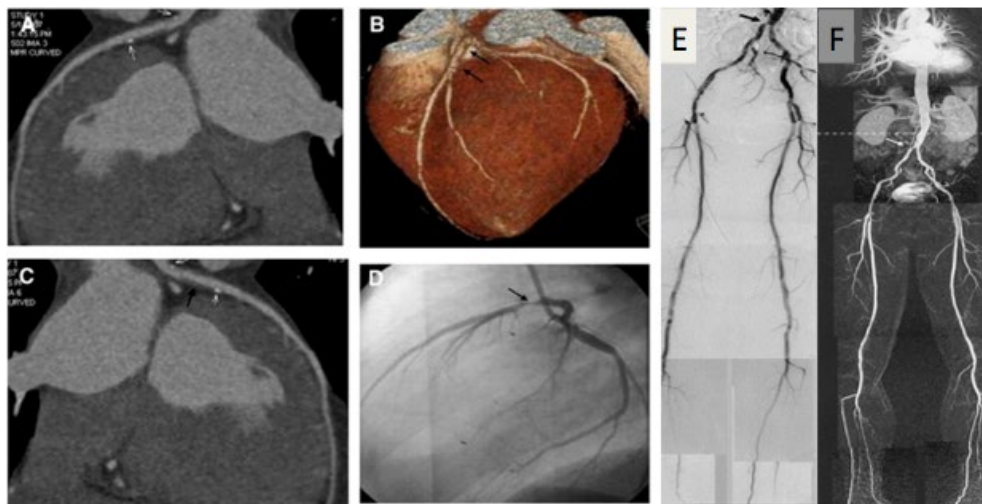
A) Coronary CTA maximum intensity projection images reveal plaque in proximal segment of left anterior descending artery (LAD) with calcification (white arrow). B) Volume rendering show plaque accumulation in proximal segment of LAD (black arrow). C) Maximum intensity project show calcified plaque in proximal segment of LAD. D) CTA image clearly shows severe stenosis in coronary artery (black arrow). (E) DSA and (F) MRA images of stenotic proximal iliac artery, shown by black and white arrows. Subfigure A-D adapted from Yorgun et al.⁴⁰ Subfigures C and D are adapted from Ruehm et al.⁴¹
